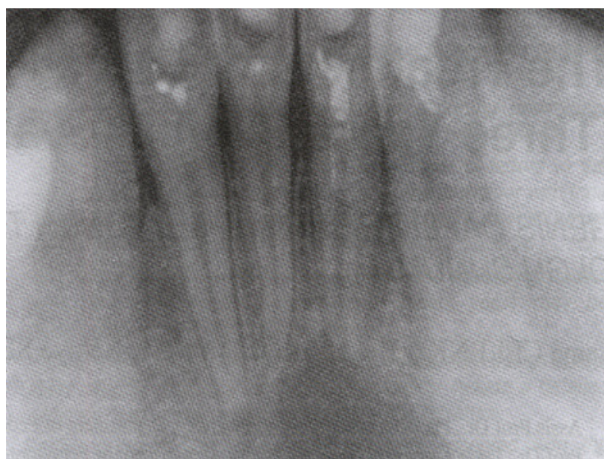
The radiographic evaluation of case (after 3 months).
